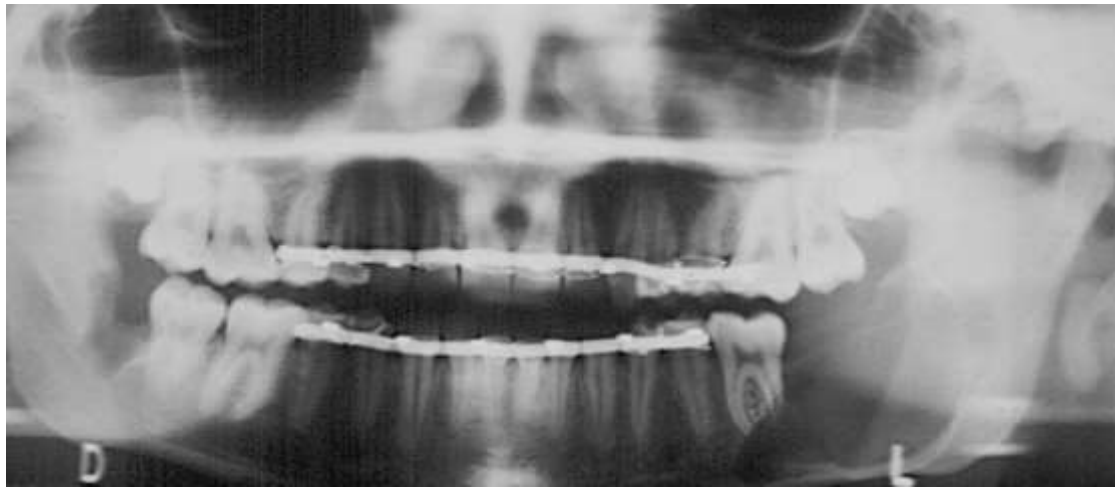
b- panoramic radiograph at one week.
